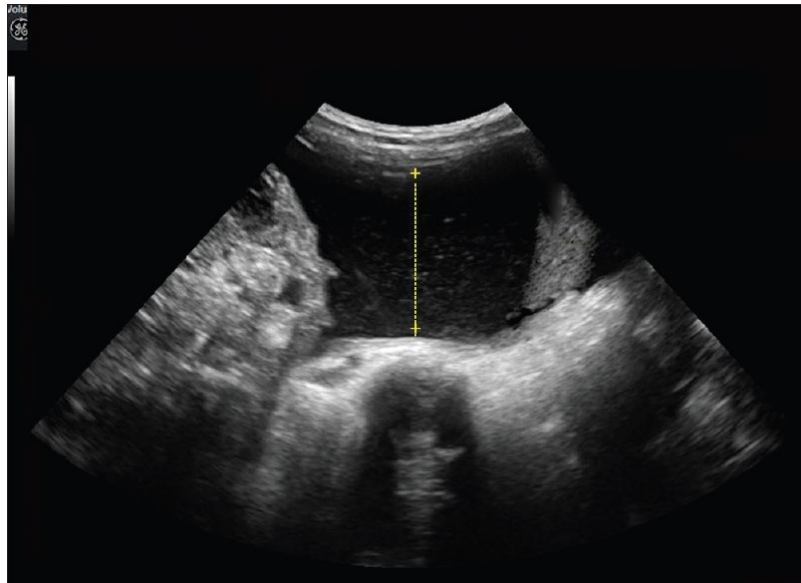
An ultrasound picture showing ascites .
